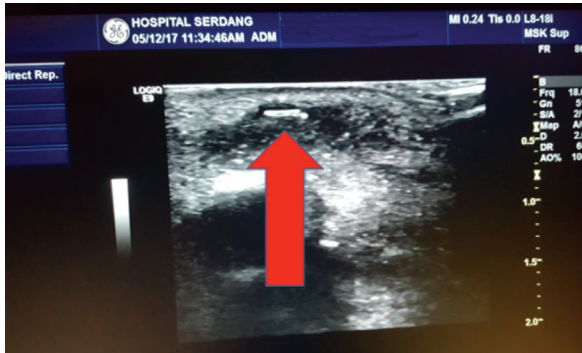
The ultrasound image of the palm oil thorn (red arrow)
